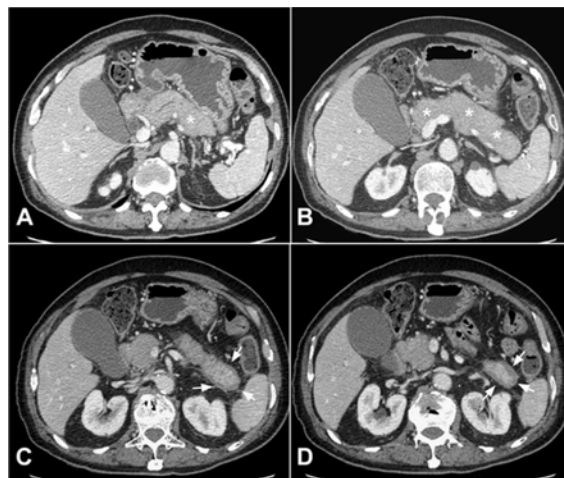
Serial axial CT images of pancreas (1A-1D from craniocaudal direction) show a diffusely enlarged pancreas with poor enhancement (* in 1A, 1B) and capsule-like rim at pancreatic tail (white arrows in 1C, 1D)
